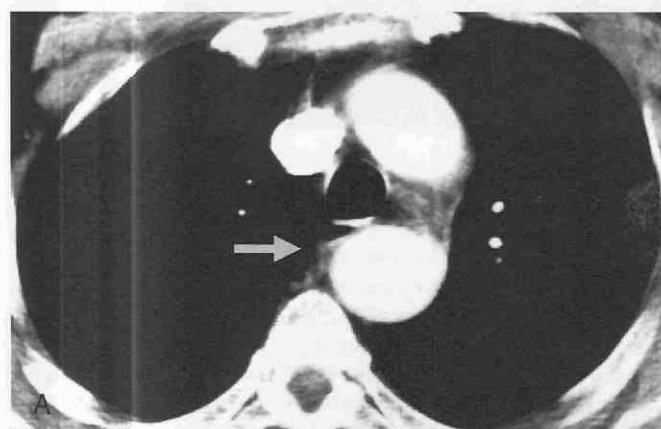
A, Axial CT scan shows the origin of the right subclavian artery from a diverticulum of Kommerell (arrow). B, Axial CT scan shows compression of the esophagus by the aberrant right subclavian artery (AbRSA).
